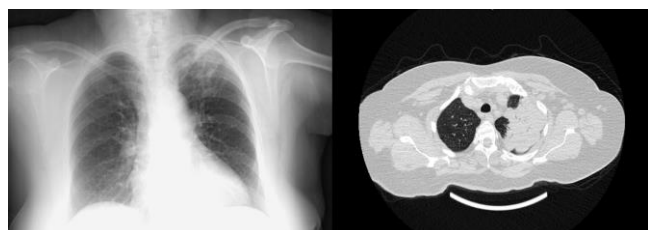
Chest X-ray and thoracic CT taken 5 years earlier revealing consolidations in the left upper zone and the left upper lobe
